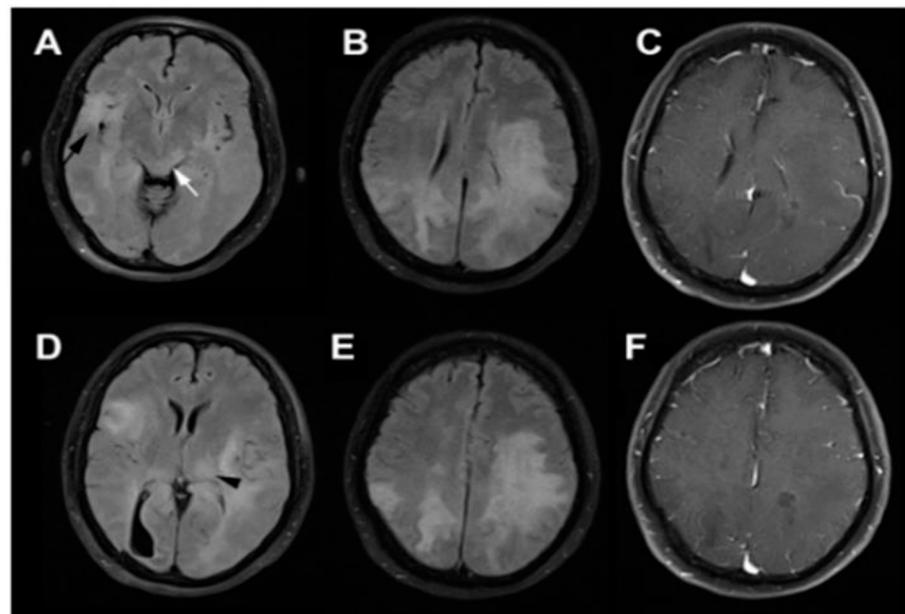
Fluid-attenuated inversion recovery (FLAIR) images show diffuse confluent white matter hyperintensity particularly at the left-side (A-D) without significant enhancement on T1-weighted brain MRI (C, F). Involvement of (black arrow), deep gray matter (black arrowhead), and dorsal midbrain (white arrow) is evident. From Abdi S et al. [123]
